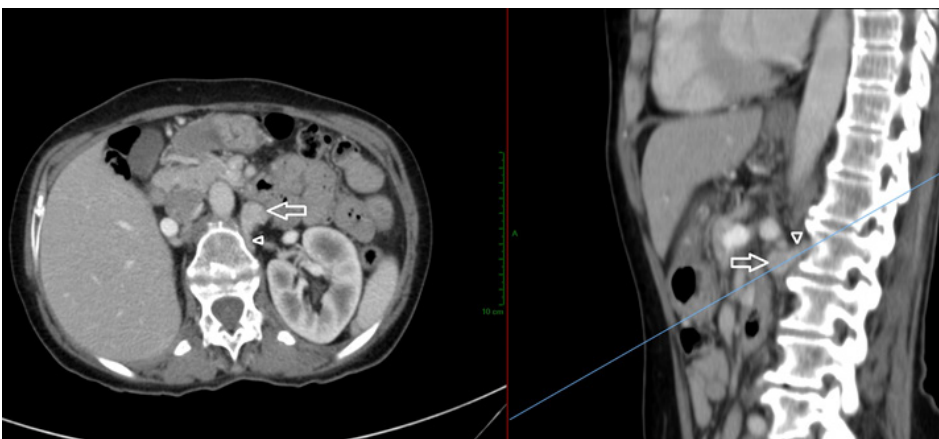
Axial oblique CT image, and the corresponding level on sagittal at the right side of the image, putting in to better detail the communication of the varix (arrow) with the left ascending lumbar vein (arrowhead).
